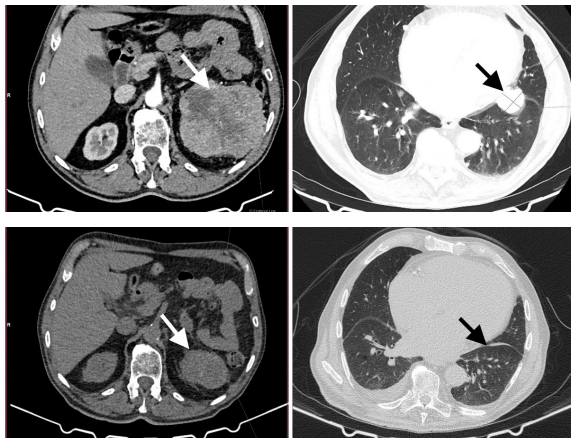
A baseline CT revealed a 96-mm-sized primary tumor in the left kidney and a metastatic tumor in the left lung (A, B). The best overall response with reduction in diameter in both target lesions (C, D)
